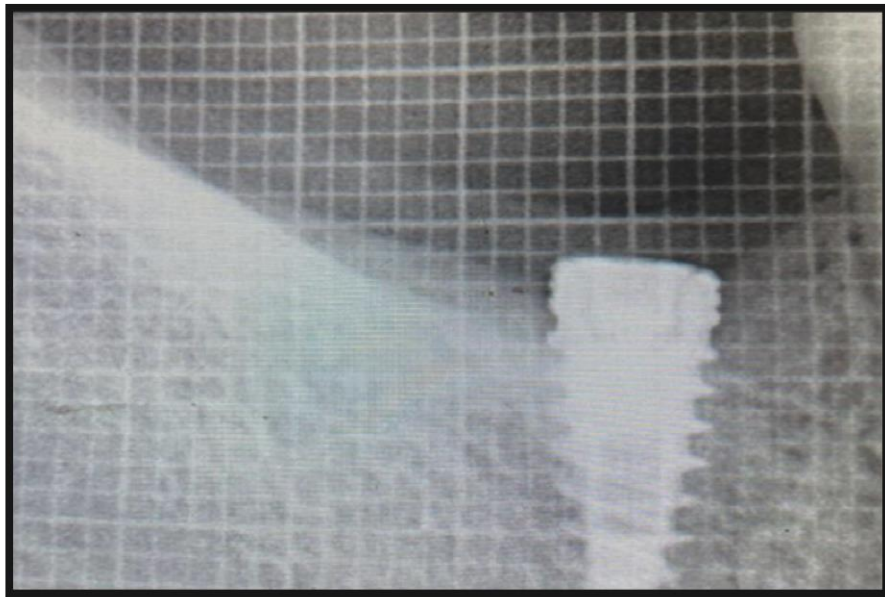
Radiograph at three months
